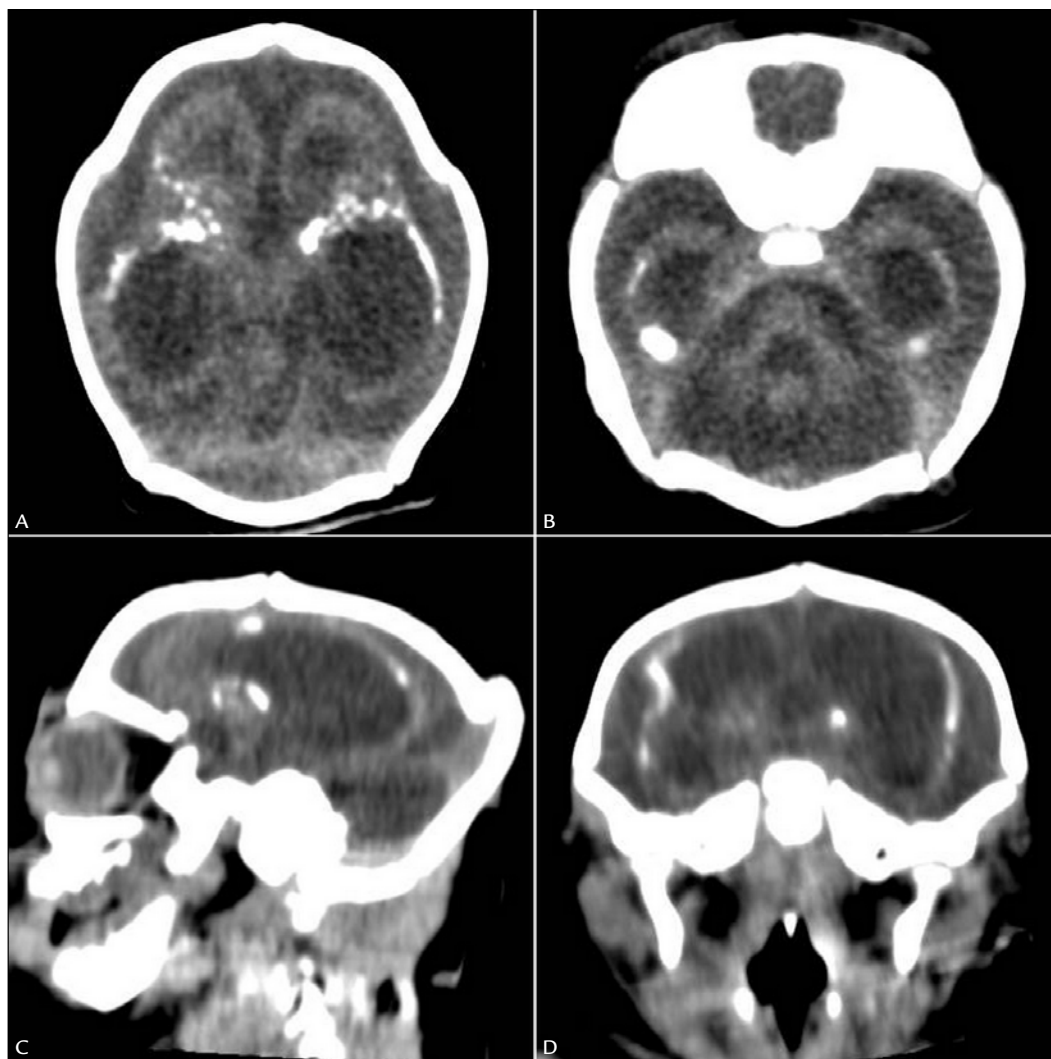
Computed tomography of the newborn characterizes markedly dilated lateral ventricles, cerebral parenchyma with signs of marked volumetric reduction, extensive periventricular calcifications and simplification of the cerebral convolutions (lissencephaly).
